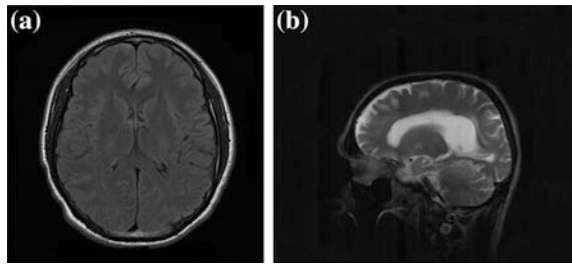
a Normal brain MRI. b Abnormal brain MRI
